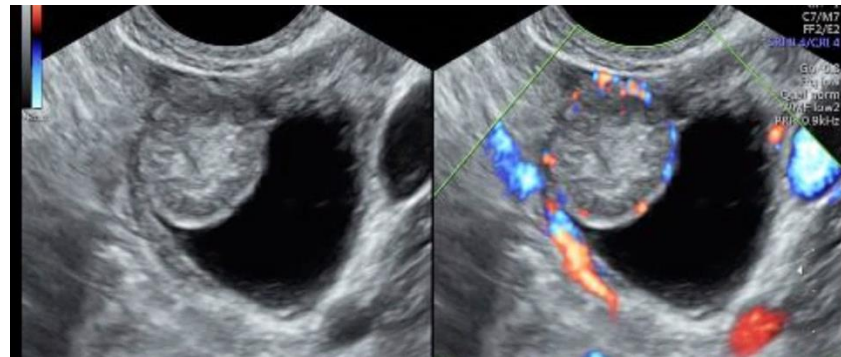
Ultrasound appearance of a complex left adnexal structure inseparable from the right ovary. Cystic component measured up to 27mm while solid component measured 17mm and demonstrated peripheral vascularity. normal stomach was noted.
